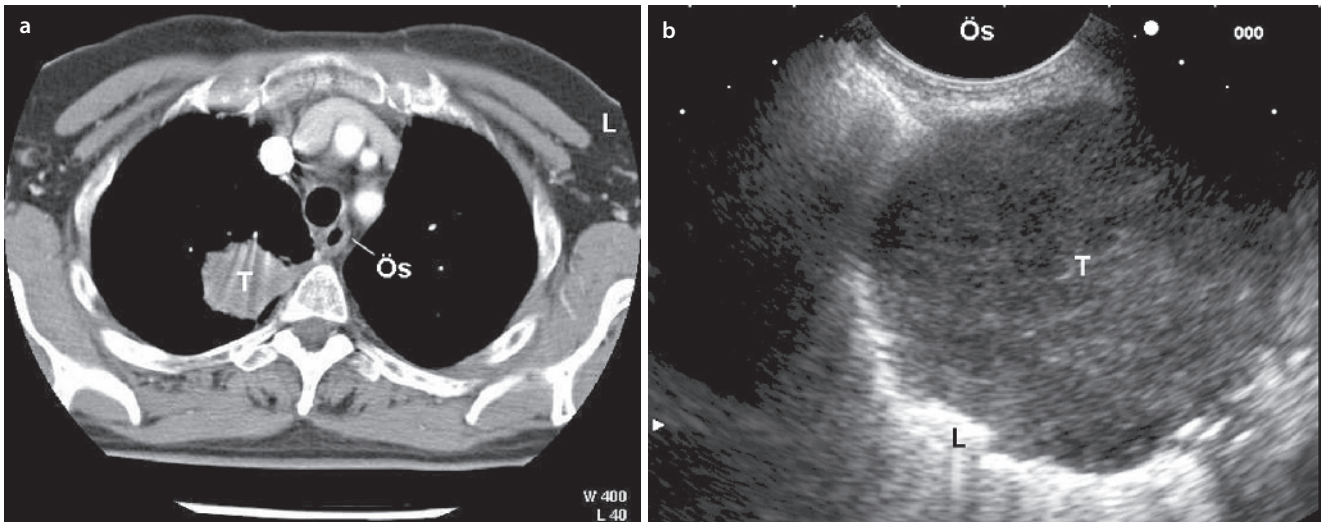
a Computed tomography of the thorax. Relatively smooth shaped intrapulmonary lesion (T) located in the right upper lobe (3 cm × 3 cm × 6 cm) located adjacent to the esophagus (Ös). The
